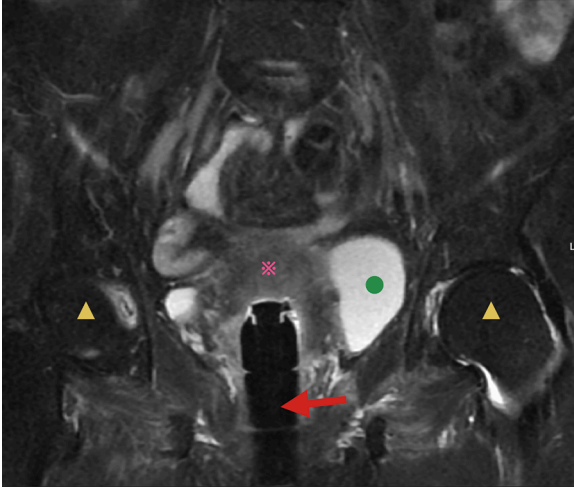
Coronal T2-weighted magnetic resonance image of applicator used in vagina and surrounding organs and tumor. Red arrow, yellow triangles, and green circle designate a commercially available applicator, femoral heads, and bladder, respectively. Asterisk indicates a tumor.
